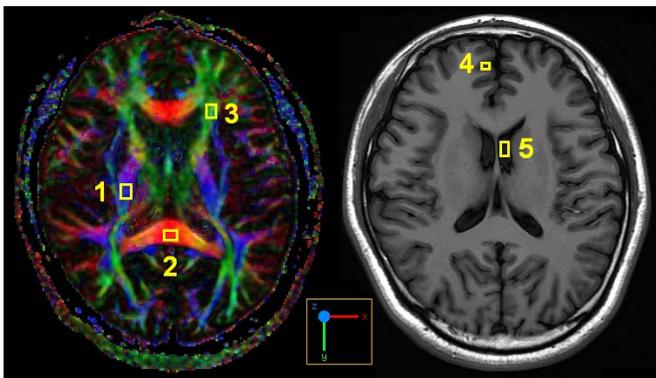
ROIs selected on a DTI colormap (left) and T1-weighted image (right), ROIs 1-3 from white matter fiber tracts with mutually orthogonal orientation, ROIs 4 and 5 from gray matter and CSF.
